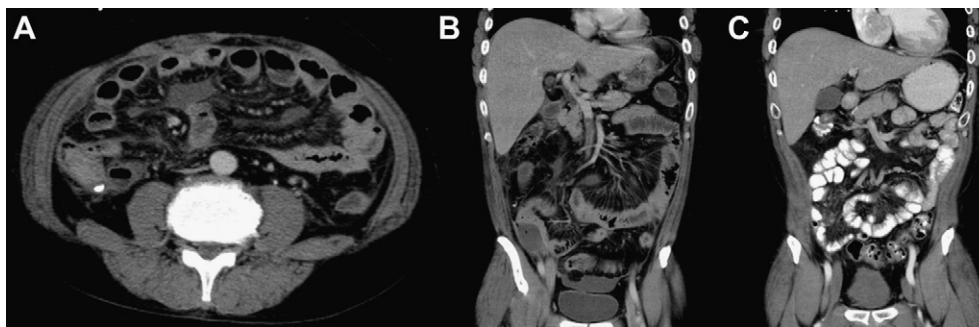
(A) CT of the abdomen showed loculated abscess collection with air fluid levels and fecalith in the retrocecal area; (B) thrombosis in the main trunk of the SMV; (C) follow-up CT 3 months later showed resolution of the SMV thrombosis. CT = computed tomography; SMV = superior mesenteric vein.
